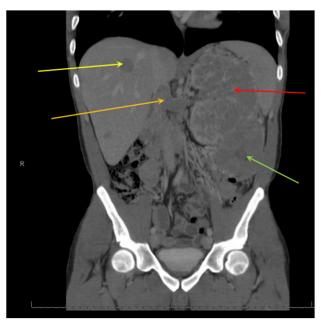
Computed tomography findings for a 25-year-old man. The red arrow indicates a large heterogeneous mass arising from the left kidney replacing the left renal parenchyma. The green arrow indicates an exophytic lesion arising from the lower pole of the left kidney, which measures 8 cm. The gold arrow indicates extensive thrombus within the left renal vein, which extends up to the intrahepatic inferior vena cava. The yellow arrow indicates a rounded hepatic mass compatible with metastasis measuring up to 3 cm.
